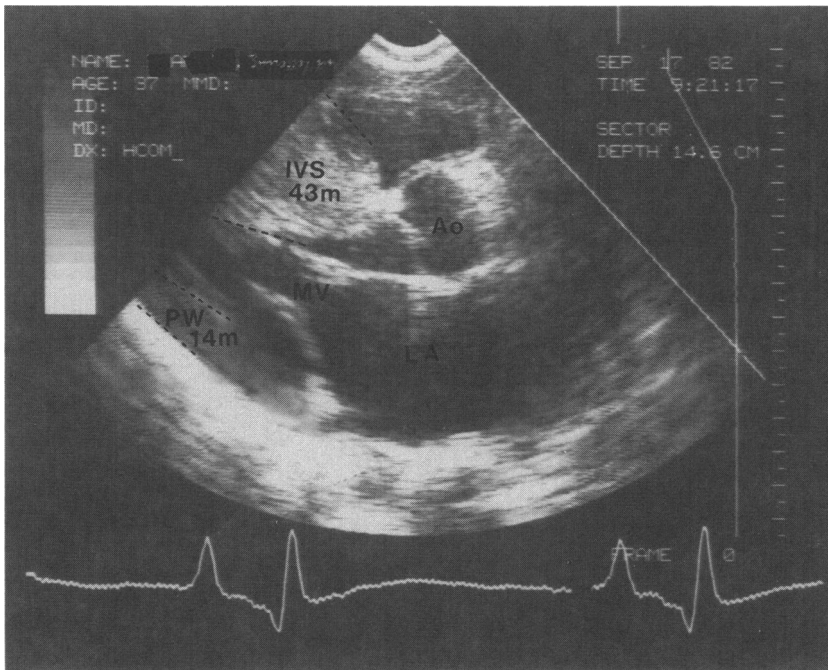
Hypertrophic cardiomyopathy or idiopathic hypertrophic subaortic stenosis (IHSS). In this parasternal long axis view is shown a very thick interventricular septum (IVS) measuring 43 mm (Normal  $\leq 11$  mm). Also, an abnormal speckling pattern of the myocardium, typical of the myocardial disarray is evident.
